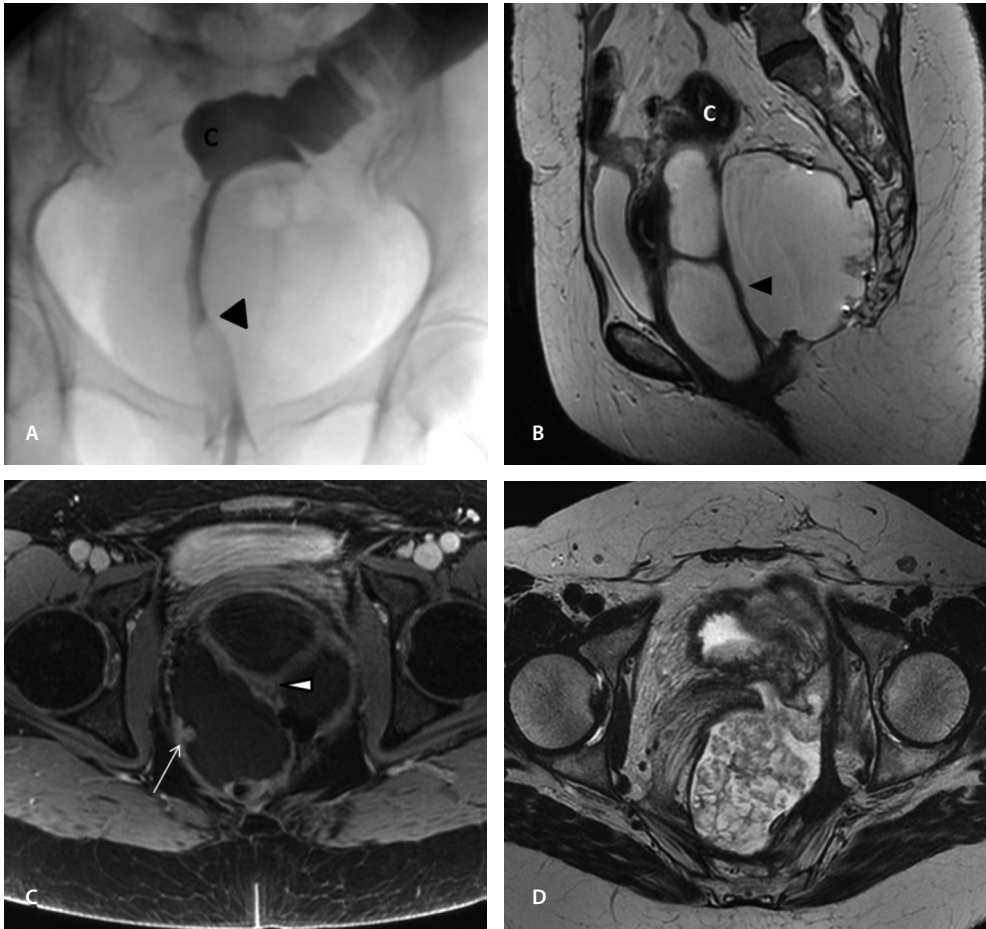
50-yearold woman with subperitoneal mucinous adenocarcinoma from colorectal origin, after rectum resection and colonic-anal anastomosis 25 years ago. A) Barium enema image for evaluation of obstructed defecation reveals an elongated stenotic aspect at the anastomotic level (arrowhead). B) Sagittal T2W MR image demonstrates a large multiloculated cystic lesion wrapped around the elongated stenotic anastomosis (arrowhead), including suggestion of solid nodular component in the dorsal wall of the lesion. C) Axial T1W fat saturated image after iv Gadolinium administration reveals the central position of compressed lumen (arrowhead), including solid enhancing nodular component in the wall (arrow). D) Axial T2W FSE: Local recurrence with increased solid content within the cyst proved a mucinous adenocarcinoma originating from the stump of the colonic-anal anastomosis. C: colon (most distal part).
